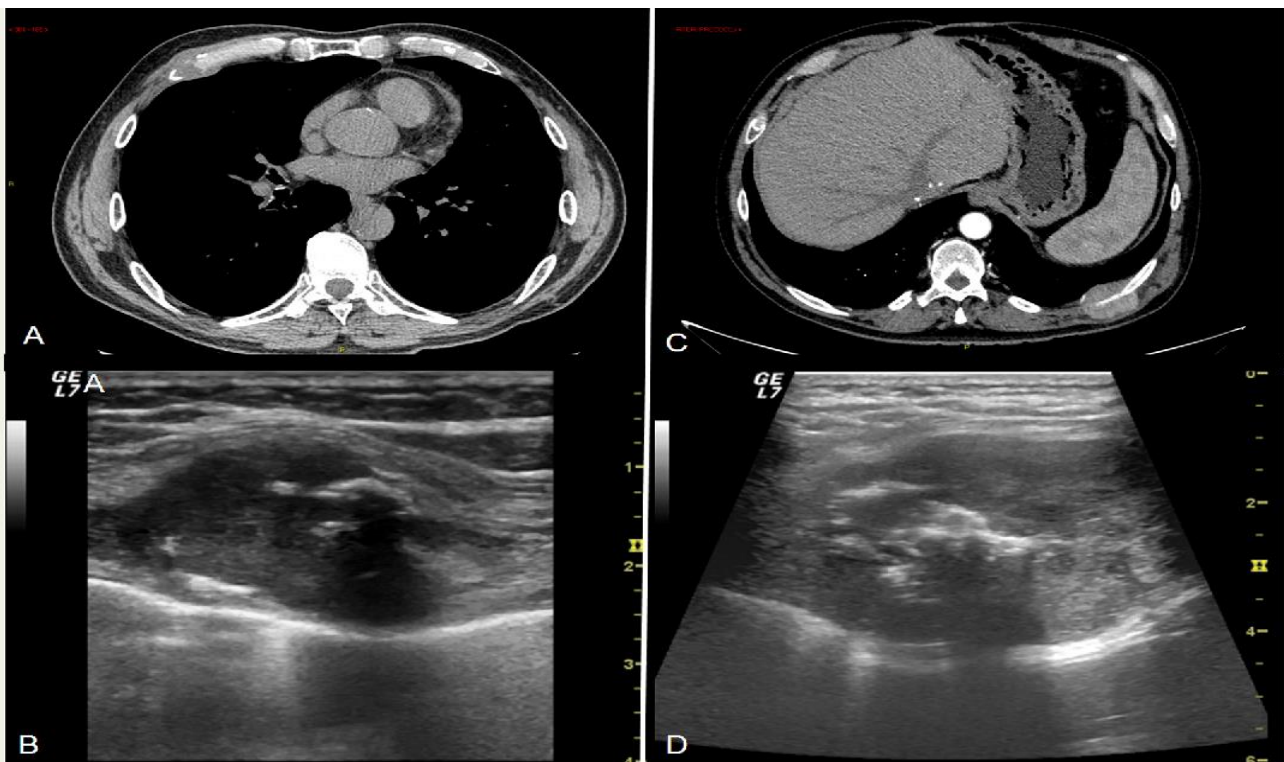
Lung Wall Cancer. Fig. 3A shows the CT scan of a fifth rib metastasis of colic carcinoma and Fig. 3B shows its Ultrasound image appearance. Fig. 3C shows the CT scan of a tenth rib hepatocarcinoma metastasis. Fig. 3D shows its Ultrasound image appearance.
